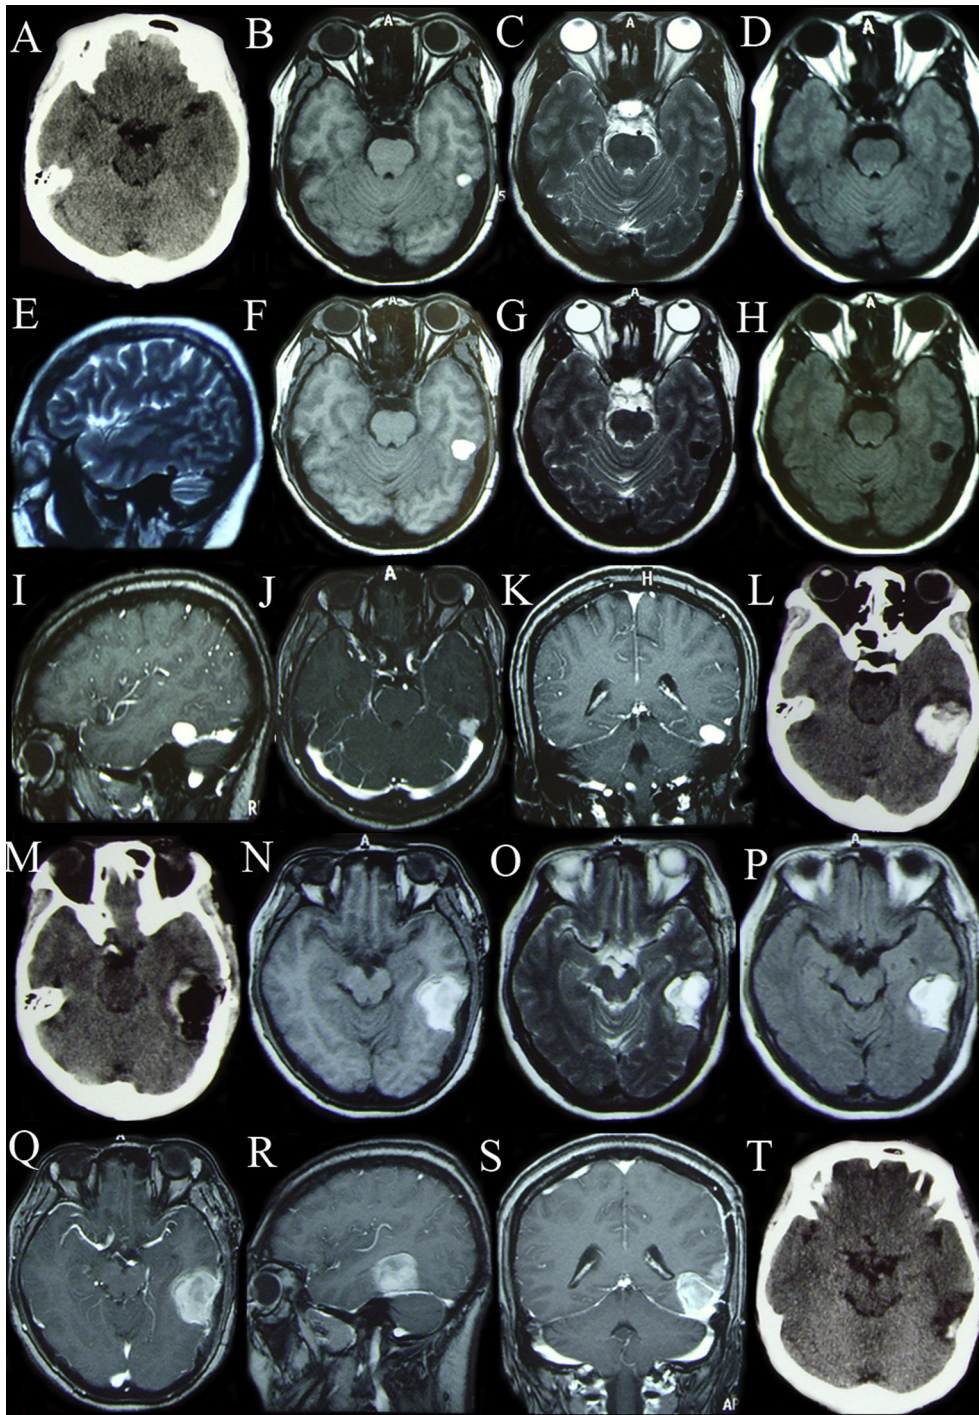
Pre- and postoperative CT and MRI scans in the patient accompanied by Nevus of Ota. (A–E) CT and MRI scans on 05/16/2009 showing a very small lesion in the tentorium cerebelli area with short T1 and T2 signals. (F–K) MRI scans on 04/20/2010 showing a slow growth of the lesion. (L) CT scans on 07/13/2011 showing a rapid growth of the lesion. (M–S) Postoperative CT scans on 07/21/2011 and enhanced MRI scans on 08/24/2011 showing complete resection of the lesion. (T) CT scans on 12/25/2011 showing the recurrence of the lesion.
